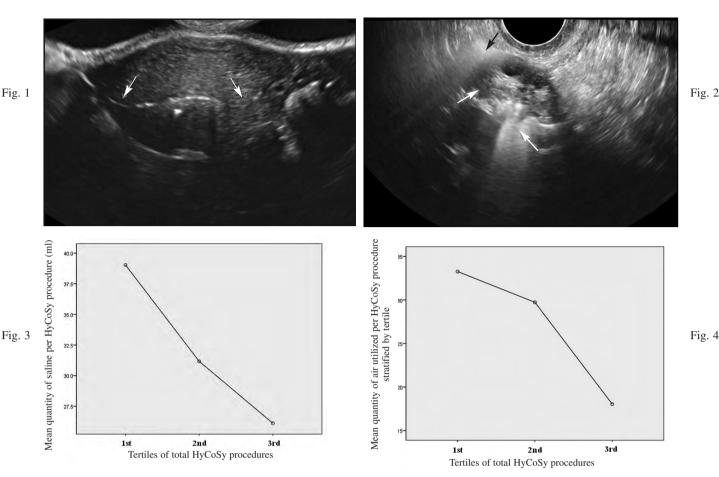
HyCoSy ultrasound still image demonstrating bilateral proximal scintillations.
